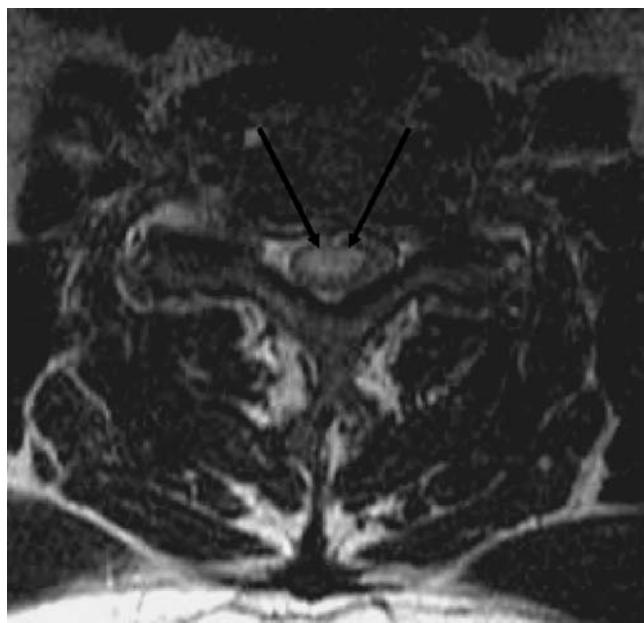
Axial T2 weighted sequence MRI showing cross-section of lesion at the level of C6-7 (arrows).
